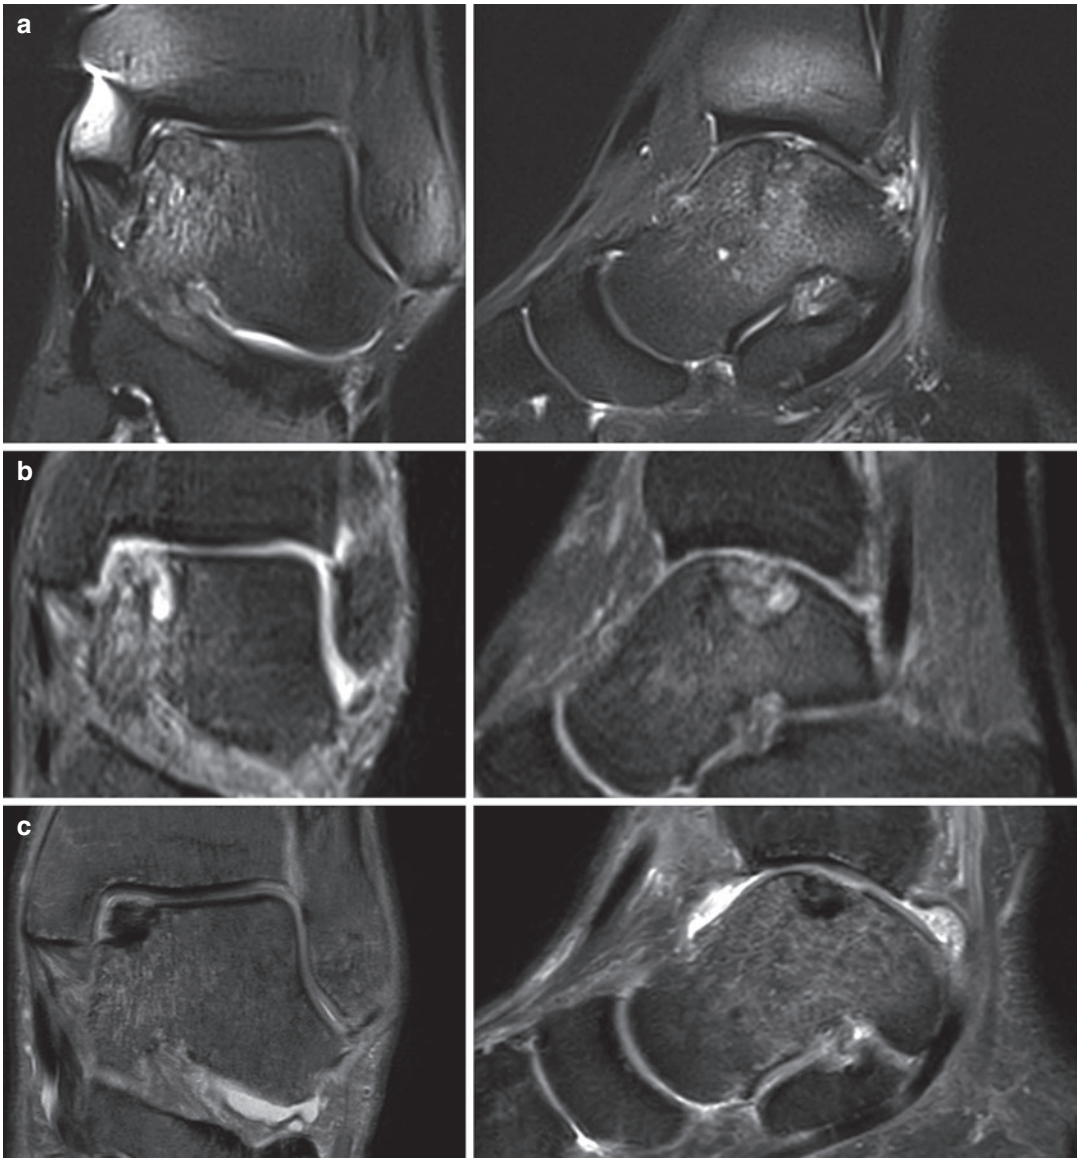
Natural history of OLT: (a) the first MRI at the beginning of the ankle pain (2 years before surgery), only chondral lesion and subchondral bone edema can be seen on the medial shoulder of the talus; (b) MRI scans 2 months before surgery, chondral lesion and edema extended and several pseudocysts appeared in the region
